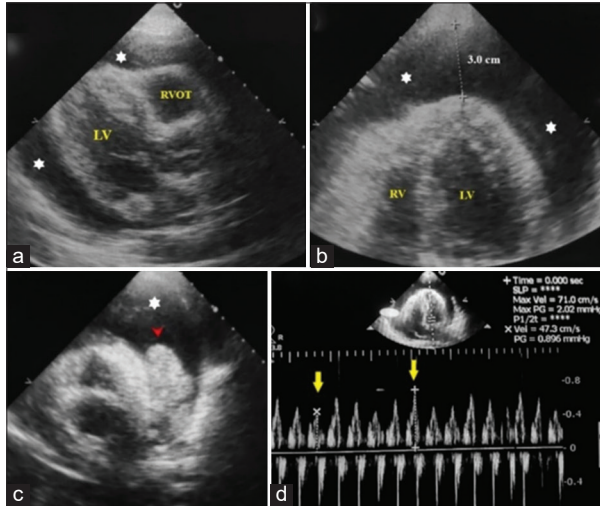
Transthoracic echocardiography in parasternal long axis and apical 4-chamber views (a-c), demonstrating large circumferential pericardial effusion (white stars). An echogenic mass lesion noted in pericardial cavity (c), lateral to the left ventricle (red arrowhead). Significant respiratory variation (33%) noted along mitral valve inflow (yellow arrows), suggestive of tamponade physiology (d). LV: Left ventricle, RV: Right ventricle, RVOT: Right ventricular outflow tract
